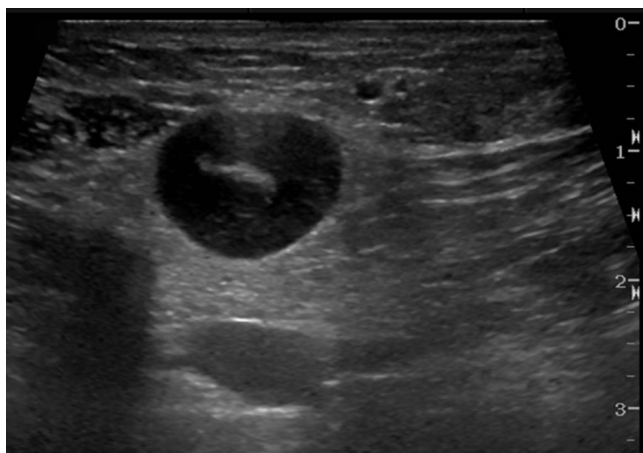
75-year-old woman with primary breast lymphoma. Ultrasound image of an axillary lymph node reveals loss of the normal reniform appearance with eccentric, bulbous cortical thickening with slitlike configuration of the hilum.
